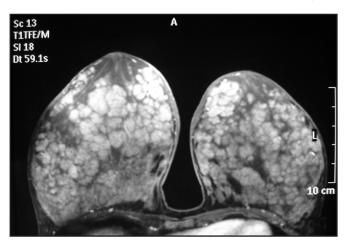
MRI Of The Breasts: post contrast T1 fat saturation showing grossly enlarged breasts measuring 18 cm x 16 cm x 13 cm on the right and 15 cm x 14 cm x 14 cm on the left with marked glandular enhancement.
